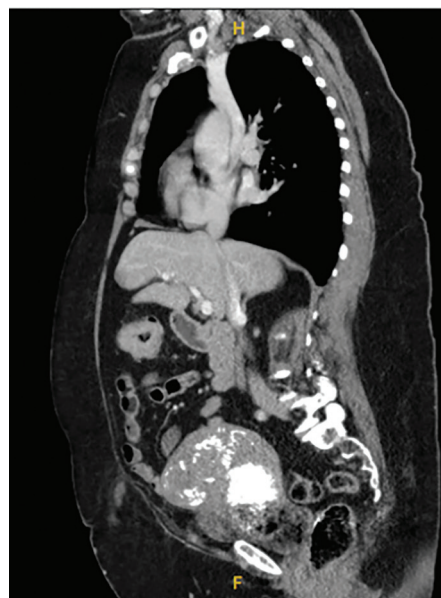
Preoperative sagittal view of CT scan for assessment of the uterus where the large fibroid made transvaginal NOSE not suitable.
